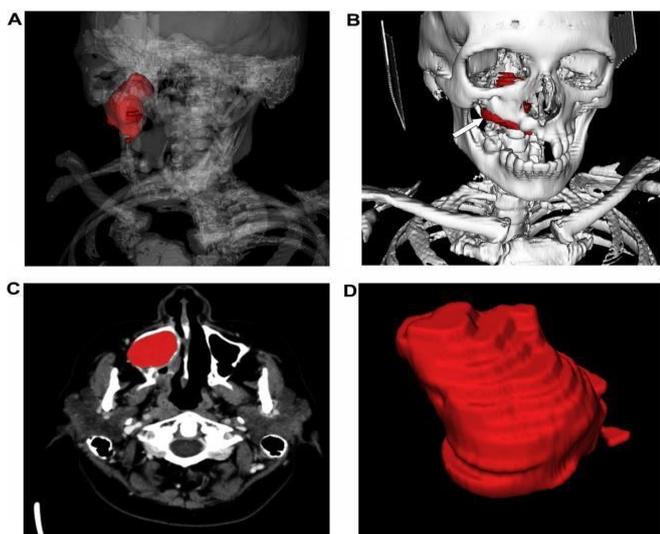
(A) Skeletal structure in isometric perspective with decreased transparency of the bone for better characterization of the neoplasm. (B) Volumetric reconstruction of the lesion within the bone structure after manual segmentation (volume measurement: 21.989.409 mm<sup>3</sup>) and automatically generated skeleton by pre-established boundaries. (C) Manual segmentation of the lesion infiltrating the maxillary sinus through the palate in an axial section of the CT scan of the neck. (D) Panoramic view of the individualized tumor after manual segmentation with volume measurement of 21,989.409 mm<sup>3</sup>.
